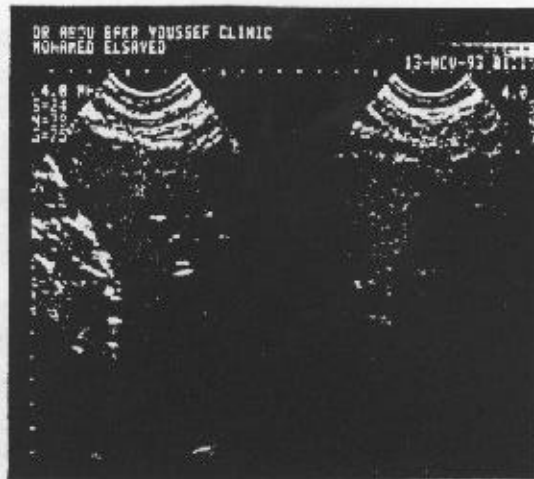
(a) Normal B-mode ultrasound image
